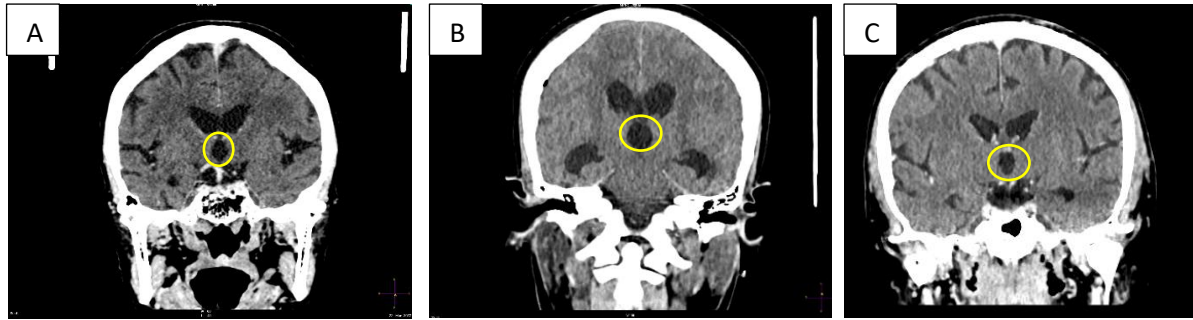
CT scans showing the different third ventricle shapes encircled in yellow, A) convex shape, B) round shape and C) straight shape.
